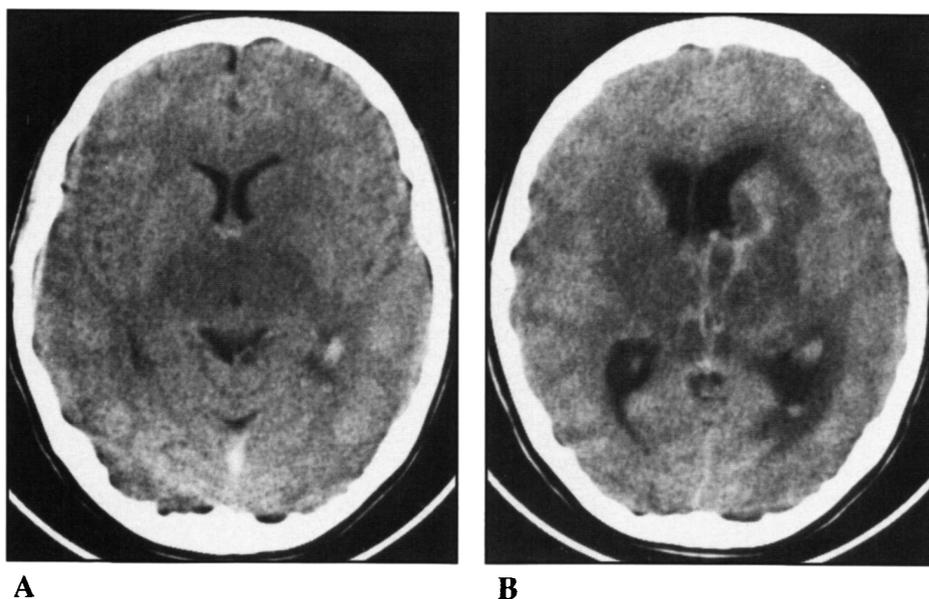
Patient 2 — (A) Non-enhanced CT on admission and (B) four days after admission. Hypodensity in both thalami, internal capsules and head of left caudate nucleus with hyperdensity in thalamostriate and internal cerebral veins, vein of Galen and straight sinus. Later CT demonstrates hemorrhage in the head of left caudate, internal capsule and both thalami. Increased surrounding hypodensity, now with moderate lateral ventricular dilatation.
